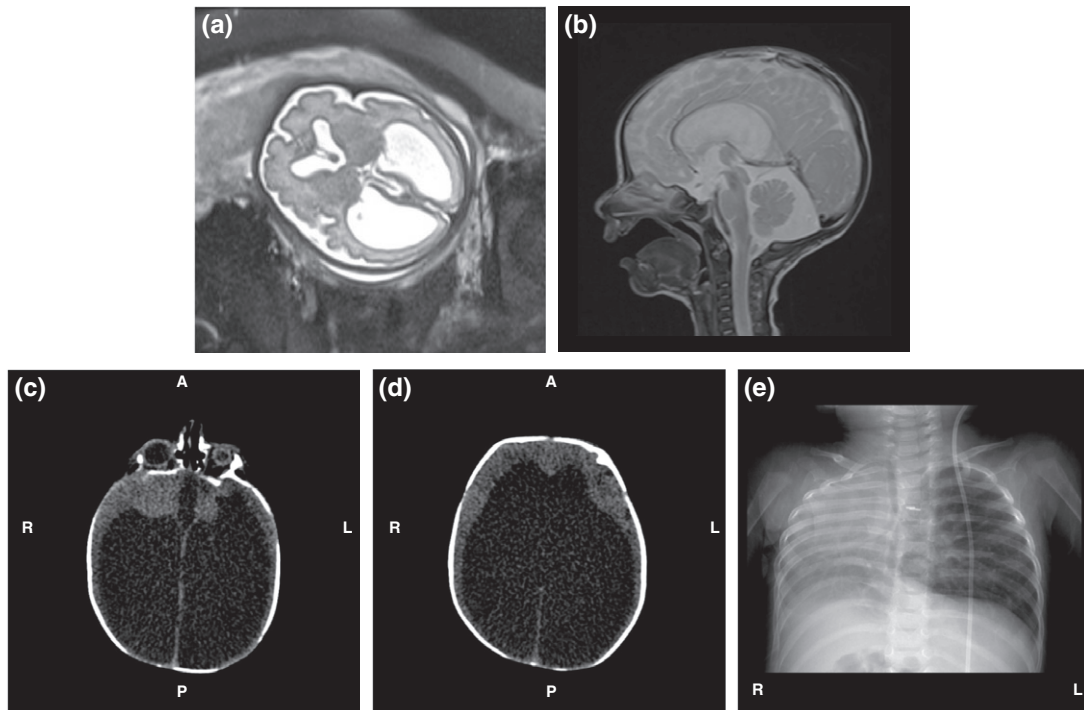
Aqueductal stenosis, hydrocephalus and lung hypoplasia in patients with bi-allelic *CRB2* mutations. Patient 1: (a) Fetal magnetic resonance imaging (MRI), showing severe ventriculomegaly with a normal posterior fossa, and (b) a post-natal pre-operative MRI (sagittal T2 weighted) showing aqueductal stenosis. Patient 2: (c, d) Cranial computed tomography (CT) at age 5 days, showing severe obstructive triventricular hydrocephalus – aqueductal stenosis, absence of septum pellucidum with a normal posterior fossa. Differential diagnosis was holoprosencephaly. (e) Chest X-ray at age 9 months, showing tracheal deviation because of right lung hypoplasia.
